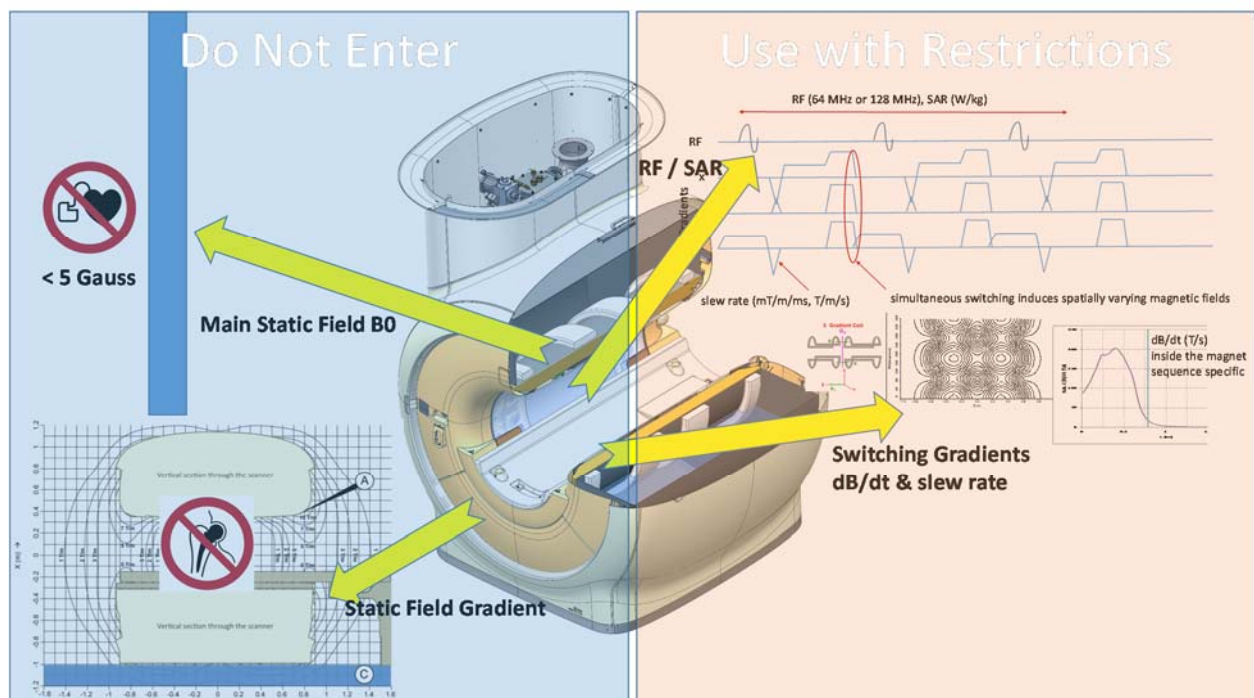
Safety concerns related to interactions between implants and MRI fields
